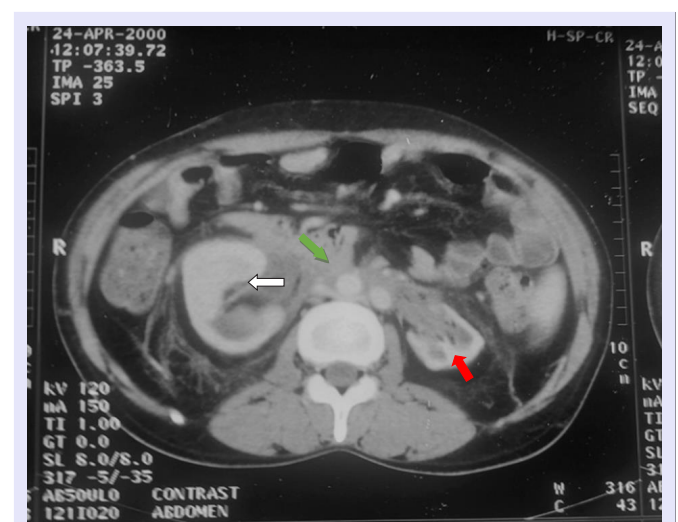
Computed tomography scan showing retroperitoneal fibrosis encasing the retroperitoneal vessels (green arrow), associated with dilation of the excretory cavities more pronounced on the right side (white arrow), and left renal atrophy (red arrow).
